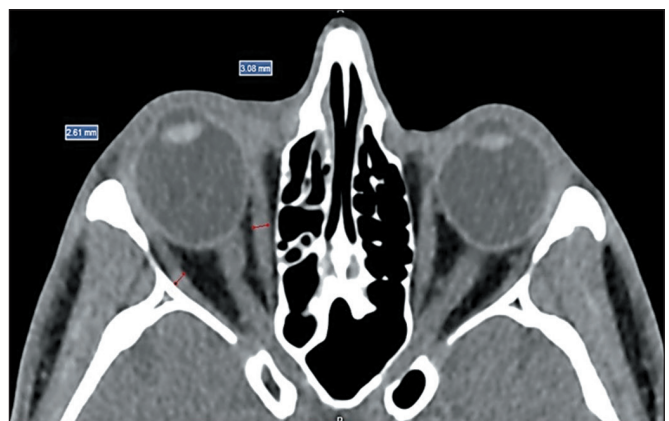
CT of orbits in the axial plane: measurement of the thickness of the muscle bellies of the MR and LR.
